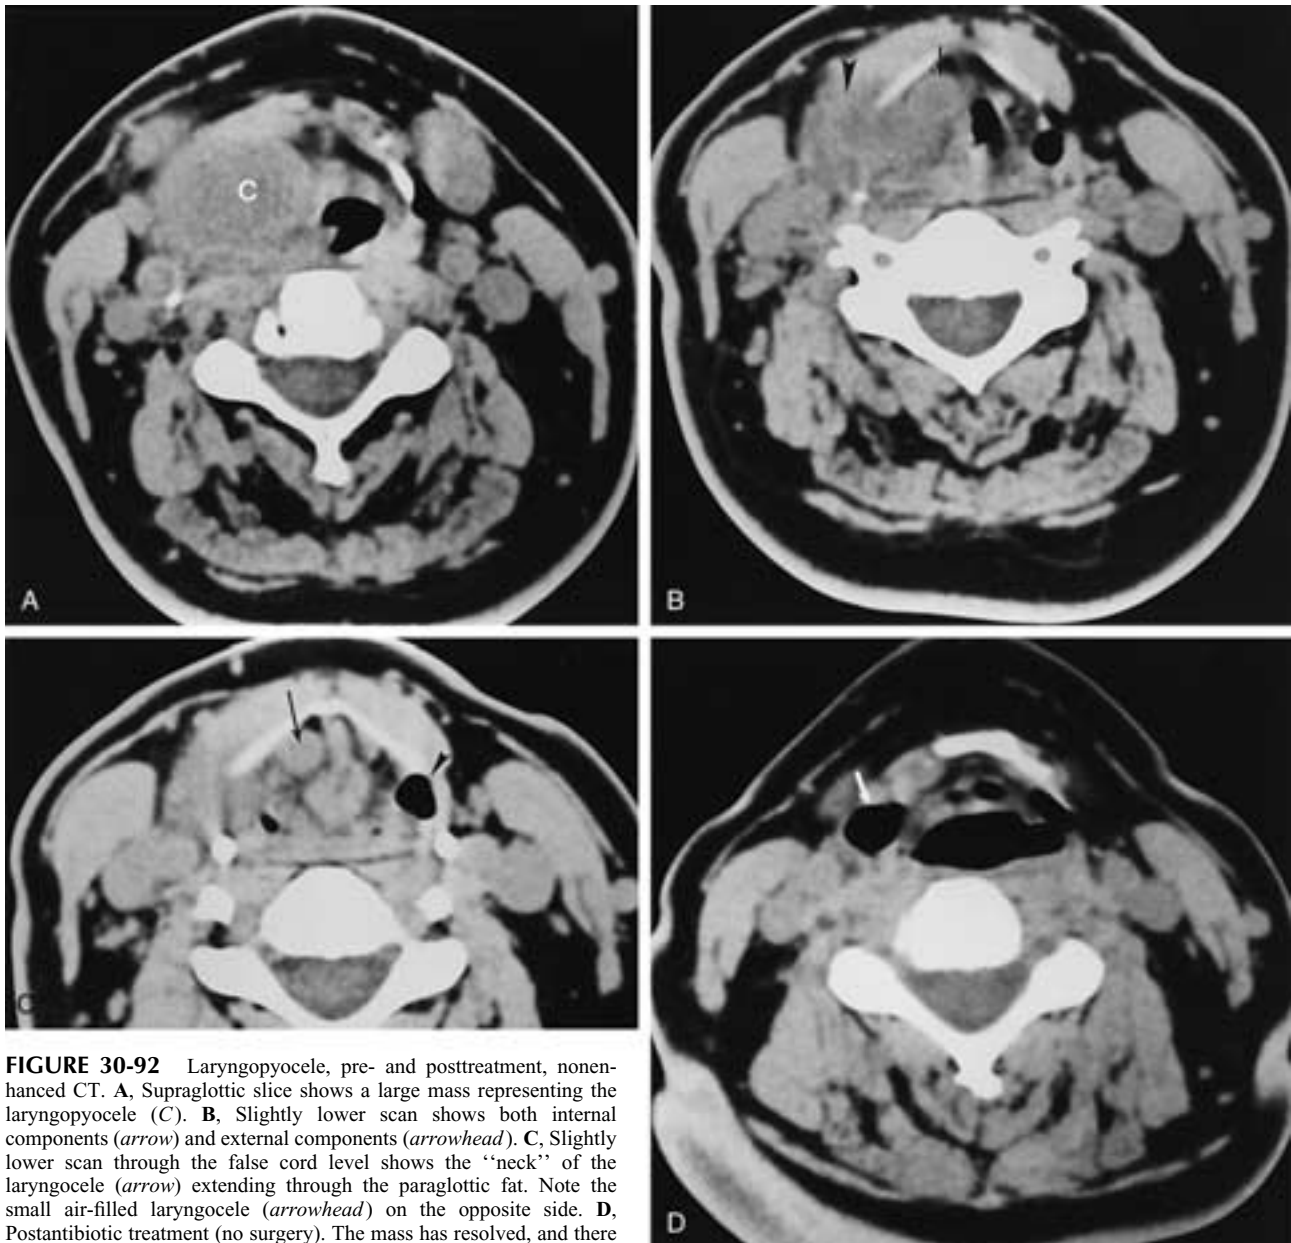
Laryngopyoceles, pre- and posttreatment, nonenhanced CT. A, Supraglottic slice shows a large mass representing the laryngopyoceles (C). B, Slightly lower scan shows both internal components (arrow) and external components (arrowhead). C, Slightly lower scan through the false cord level shows the "neck" of the laryngopyoceles (arrow) extending through the paraglottic fat. Note the small air-filled laryngopyoceles (arrowhead) on the opposite side. D, Postantibiotic treatment (no surgery). The mass has resolved, and there is air in the laryngopyoceles (arrow).
